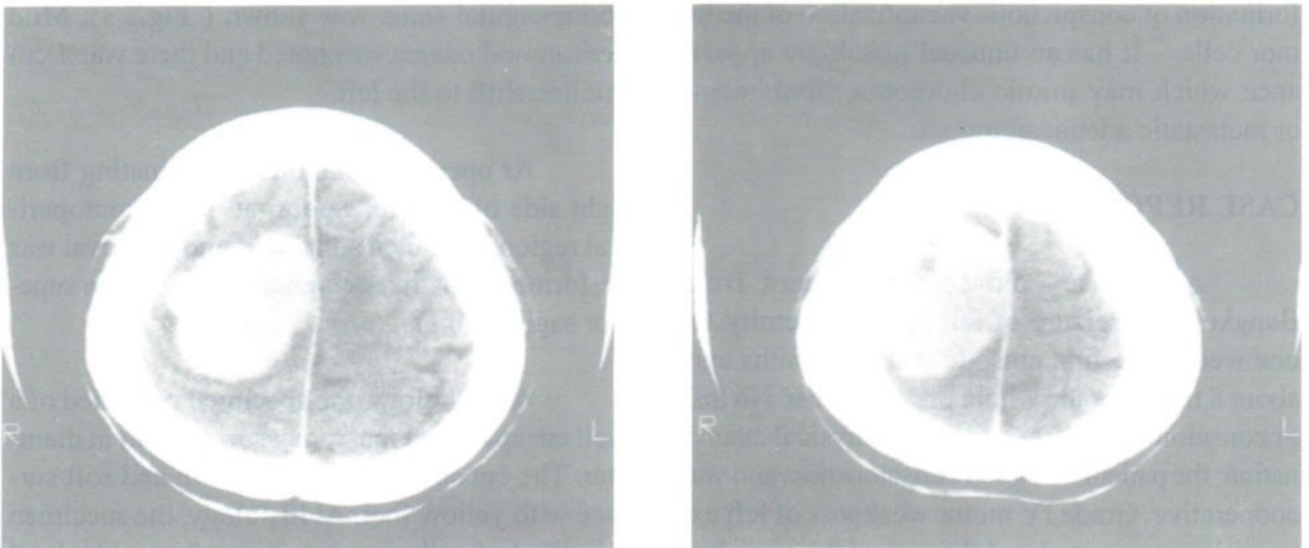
CE axial CT scan of the brain at the mass showed that the mass was densely and homogeneously enhanced. Part of its borders attached to the right frontoparietal convexity and the falx.
